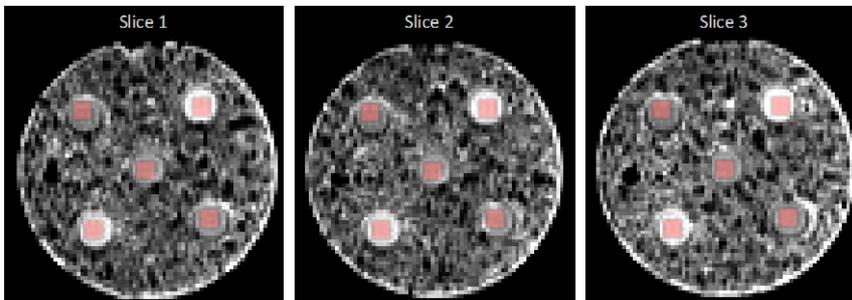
Acquired 3-slice DWI images (b 0 s/mm², TE 34 ms) of the diffuse test-object with ROIs overlain in red.
